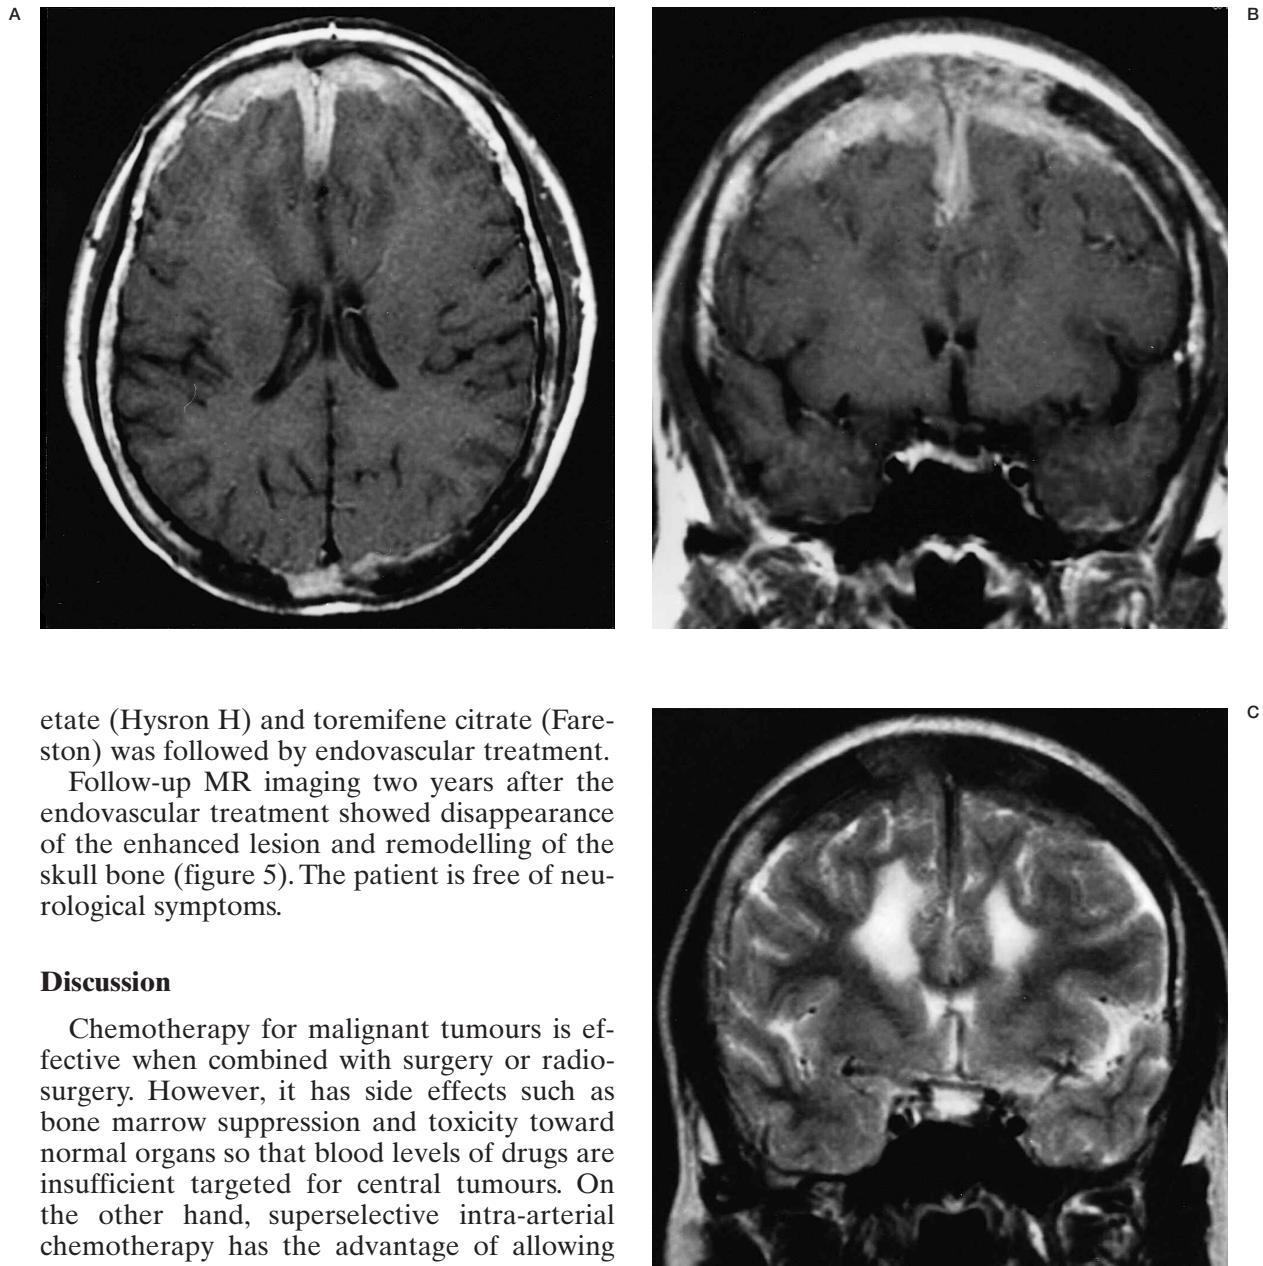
MR imaging T1-weighted axial (A) and coronal image (B) after contrast injection, and T2-weighted coronal images (C) showing abnormalities of the cranium and dura with marked brain edema.
